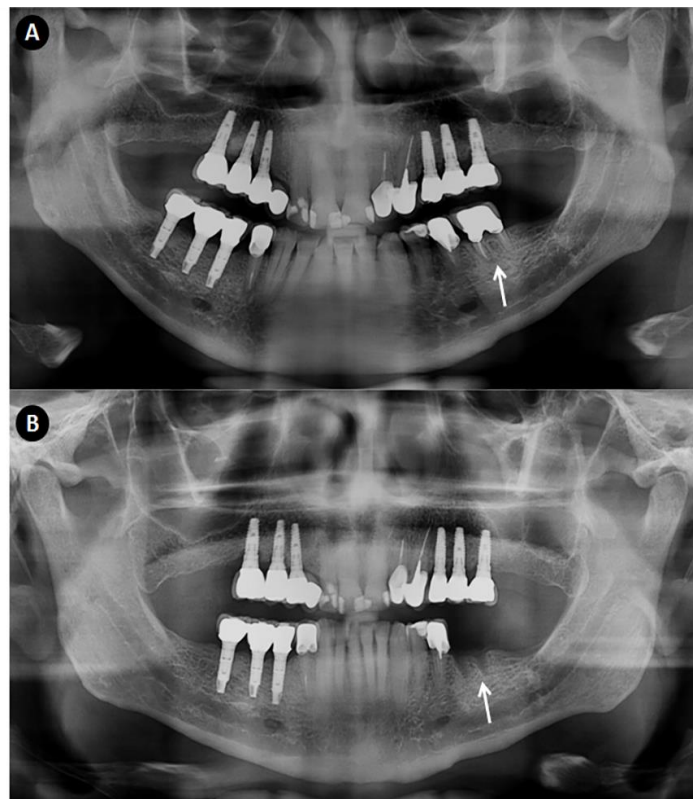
Radiographic findings in non-healing alveolar sockets associated with i.v. BPs therapy. A. Panoramic radiographic from i.v. BPs patient before tooth extraction (arrow). B. Follow-up panoramic radiographic of the same patient showing non-healing alveolar socket (arrow) 12 months after extraction.
